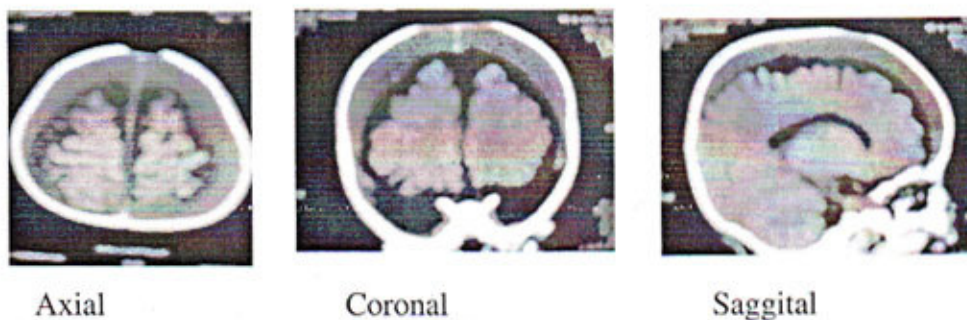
Pre-operative CT scan of brain
